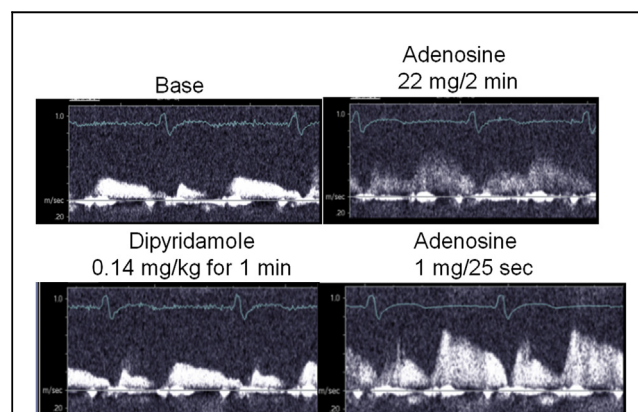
Transthoracic Coronary Doppler Ultrasound in 78-kg Patient With Normal LAD at Coronary Angiography
